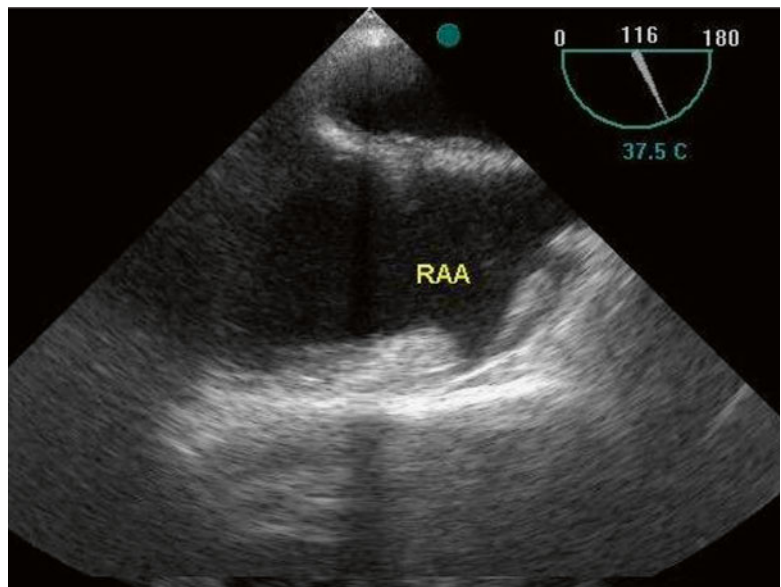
Transesophageal echocardiography, showing a broad-based. *RAA* right atrial appendage
